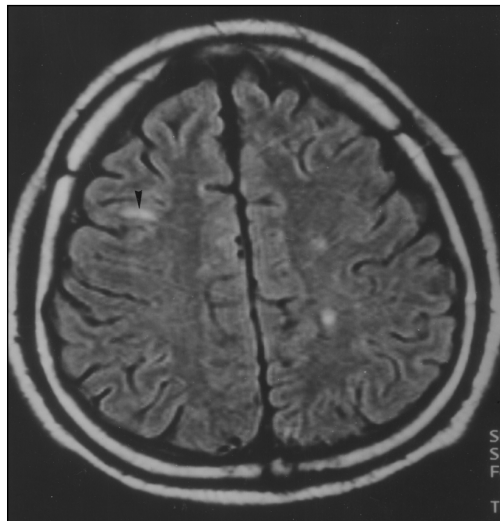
45-year-old patient with acute Nipah encephalitis. Axial fluid attenuated inversion recovery MR image shows lesions in gray matter (arrowheads).
